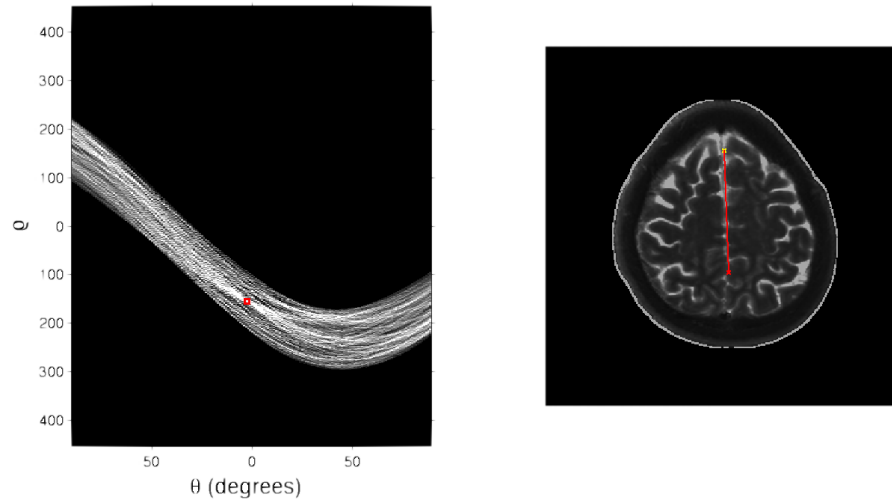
Left: The result of the Hough transform to parameter space with the strongest point marked with a red square. Right: The two endpoints of the strongest line marked with crosses and connected with a line in the MR image.
